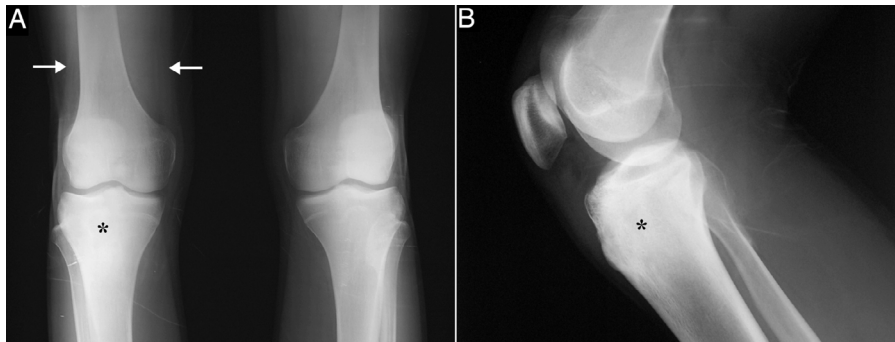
Anteroposterior radiographs of both knees (A) and lateral view of right knee (B) showing sclerosis in upper third of right tibia (asterisks) with no apparent “nidus”, and a reduction in the volume of the distal third of the quadriceps due to muscle atrophy (arrows).
